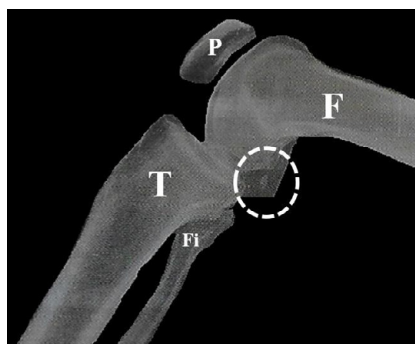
Radiograph of the right knee. F: femur; P: Patella; T: Tibia; Fi: fibula; White circle in strokes: Bone fabella.
